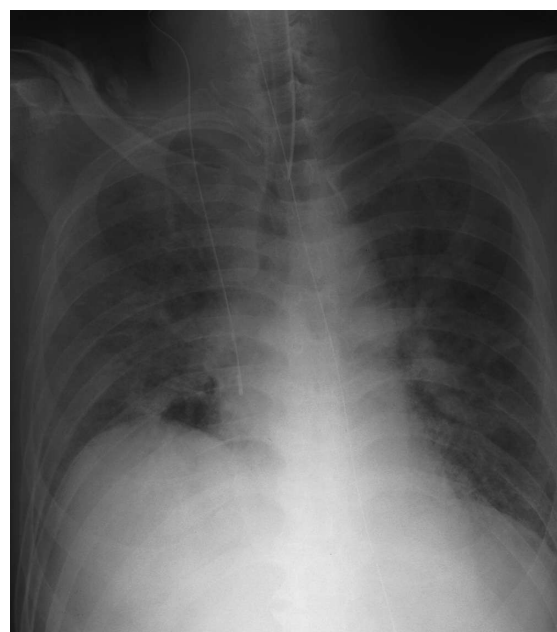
Chest X-ray film on admission demonstrated interstitial pneumonitis in both lungs.
